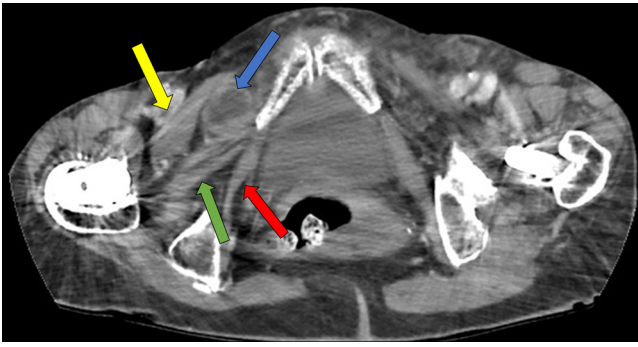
Computerized Tomography (CT) image of the pelvis injected in axial section, with reduction of metallic artifacts (s/p bilateral total hip replacement). Right obturator hernia with ileal content presenting normal enhancement (blue arrow), located between the pectineus (yellow arrow) and externus (green arrow)/internus (red arrow) obturator muscles. Be aware of the corona mortis, a common variant of vascular anastomosis between the inferior epigastric artery and the obturator artery which travels along the vascular lacuna and is in very close proximity.
